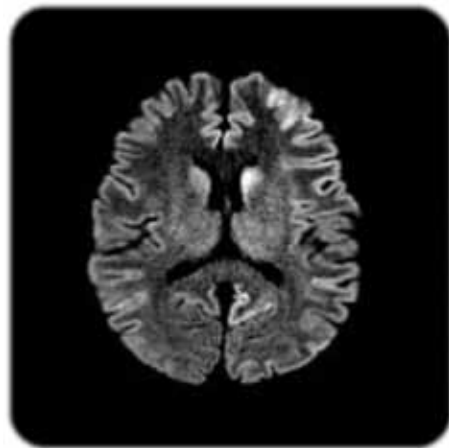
DWI sequence N. Caudatus
